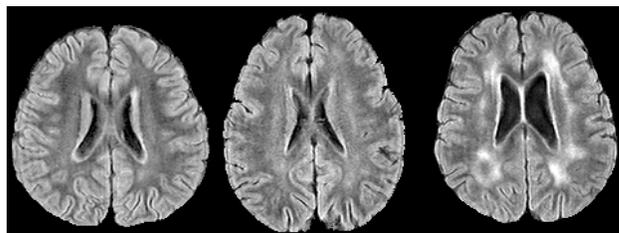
FLAIR images demonstrating normal, questionable, and definitely abnormal appearance from three different 3.5 year old children.
